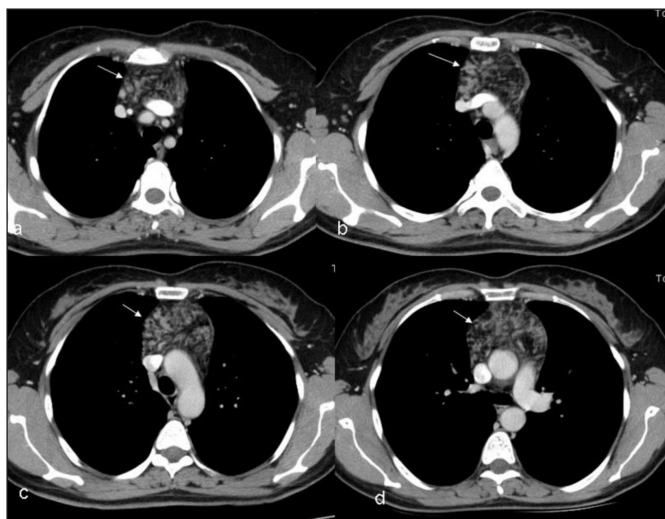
CT findings of a 34-year-old female patient show a thymolipoma typically located in anterior mediastinum.
